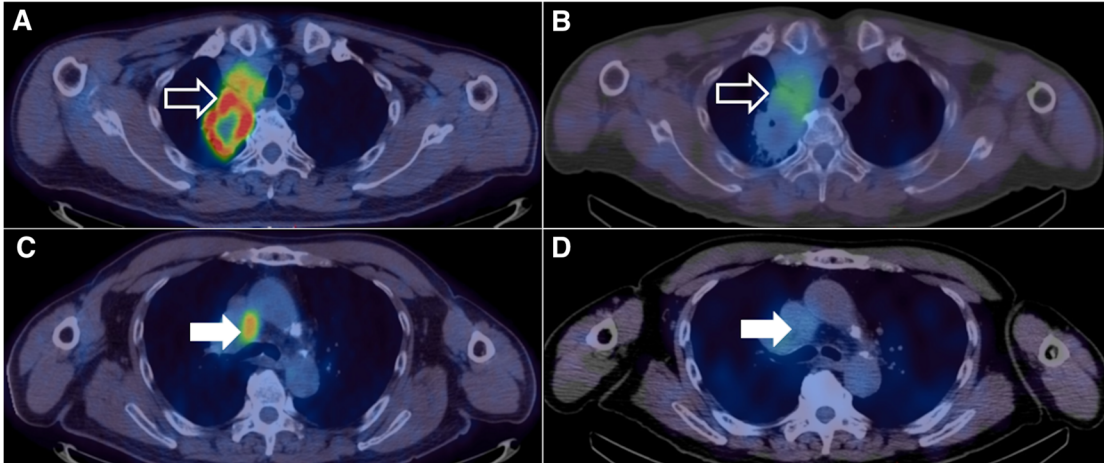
A right upper lobe tumor (open arrows) shows areas of high FDG uptake (SUVmax = 16.1) on PET/CT (A) and  $^{99m}\text{Tc}$ -SPECT/CT (T:BP = 3.53) (B) Mediastinal lymph nodes (closed arrows) show high FDG uptake (SUVmax = 6.3) (C) but low  $^{99m}\text{Tc}$ -NM-01 activity (T:BP = 1.13) (D) demonstrating heterogeneity of PD-L1 expression between primary tumor and nodal sites of disease within the same patient.
